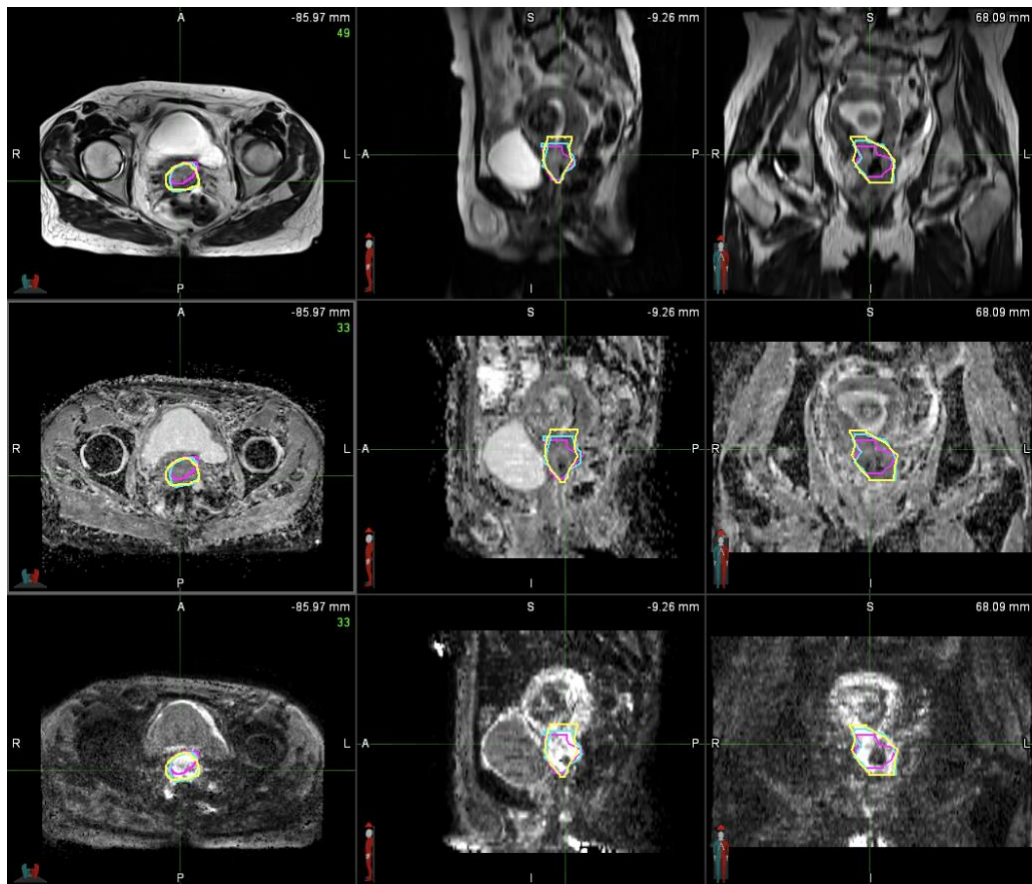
Example slice from Patient 4's a) pre-EBRT scan and b) pre-brachytherapy scan with the overlaid GTVs. The image rows from top to bottom for both scans are T2 MRI, DWI, and ADC. The GTVs contoured with the axial T2 MRI, with the axial T2 MRI/DWI fusion, and with the axial T2 MRI/ADC fusion are magenta, cyan, and yellow, respectively.
